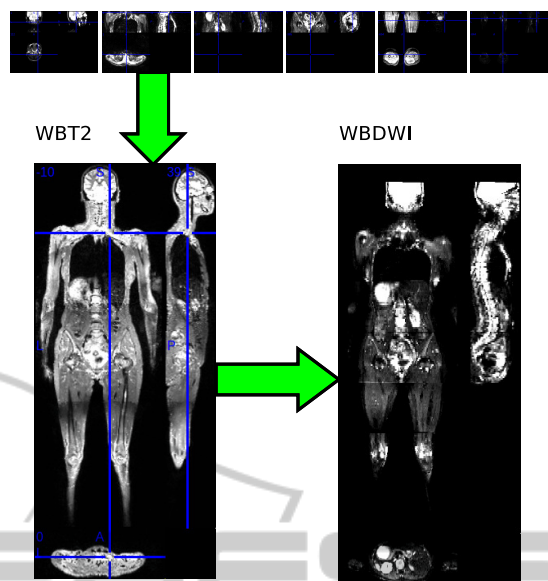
Reconstruction of whole-body DWI, each DWI sub-volumes is aligned on the reconstructed whole-body T2.
